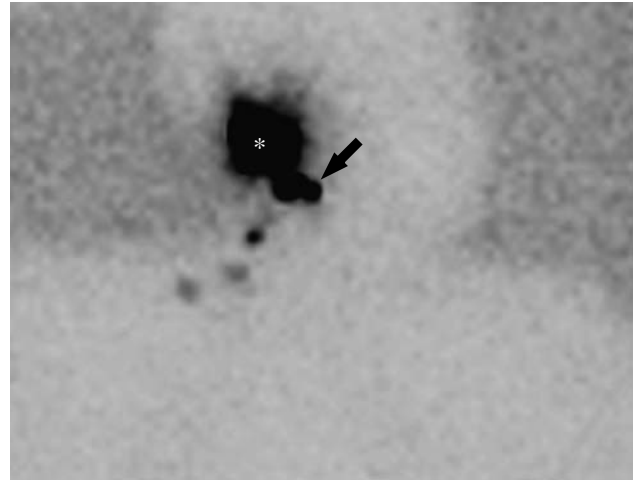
Lymphoscintigram, right lateral view, in a 63-year-old patient with right auricular melanoma. The arrow depicts a sentinel lymph node that was located in the parotid gland upon surgical exploration. (*) Injection site.
